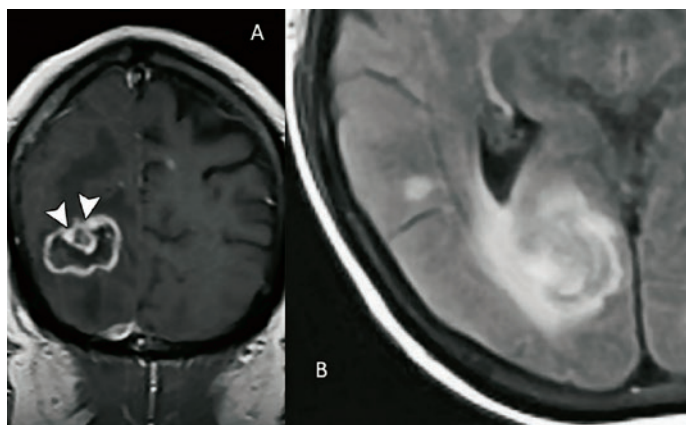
Image A displays brain MRI, coronal view, CE-T1 WI, „eccentric target sign“. Image B displays brain MRI, axial view, FLAIR, „concentric target sign“.
